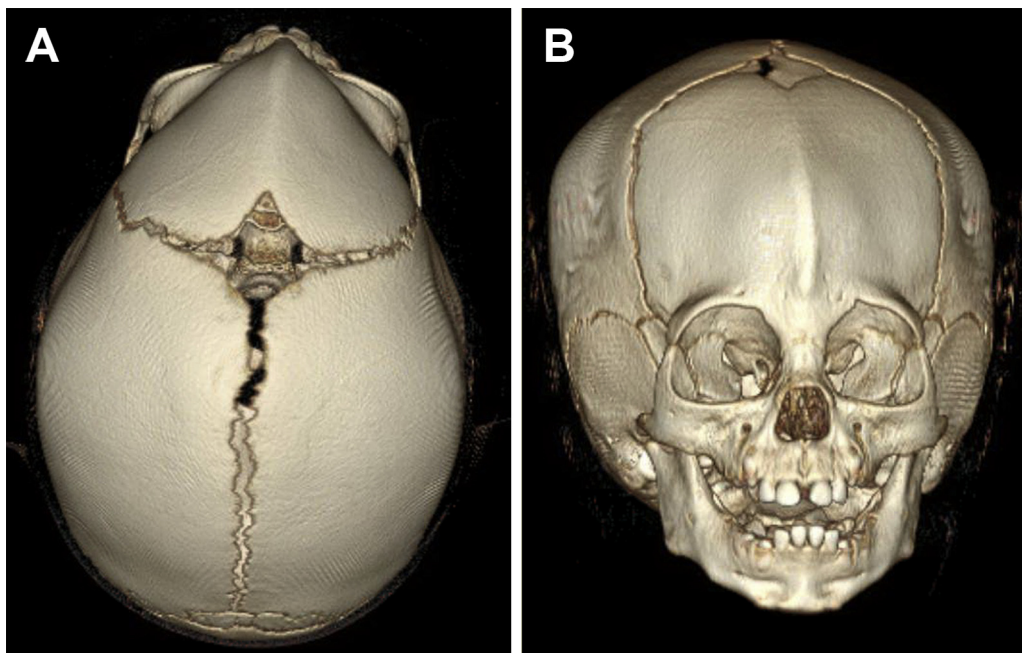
Bilateral coronal craniosynostosis. Top (A) and side (B) views of a three-dimensional computed tomography scan showing a skull short on the anteroposterior axis and wide on the transverse axis. Both coronal sutures are closed; the anterior fontanel is open in this case. (The color version of this figure is available in the online edition.)
